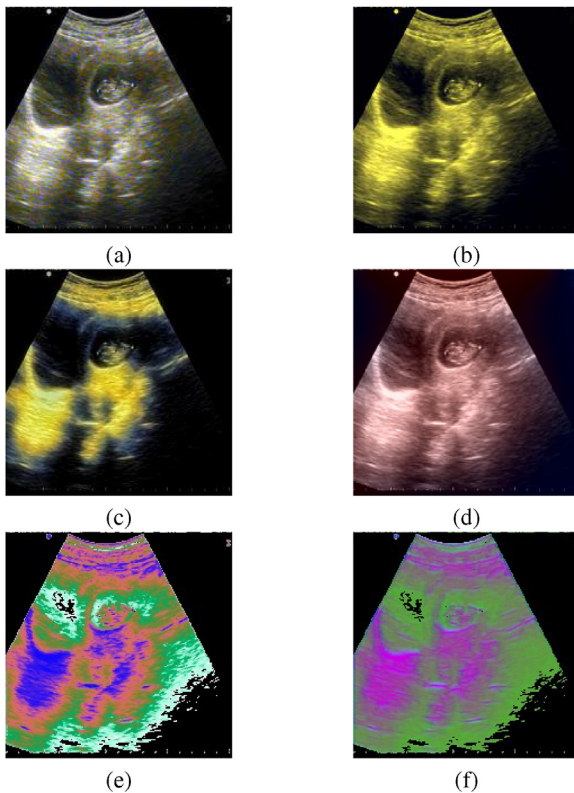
Color perception of ultrasound images. (a) TCGI [3], (b) CTCCS [5], (c) ACGCDT [6], (d) ICTED [7], (e) CPMI-DPHC(LE), (f) CPMI-DPHC(MDS). (For interpretation of the references to color in this figure legend, the reader is referred to the web version of this article.)
